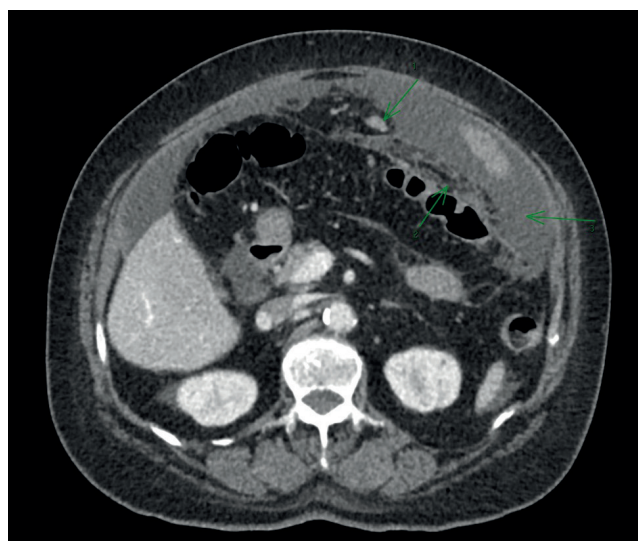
Post-contrast CT in the venous phase, axial section – reveals a juxtacentimetric iodophilic nodule, infiltrative densification of the greater omentum, and ascitic fluid in the pre-visceral space.
